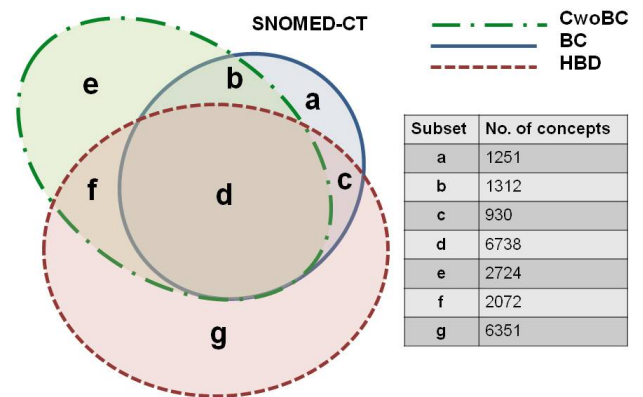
Sets of SNOMED-CT concepts for breast cancer (BC), cancer other than breast cancer (CwoBC) and heart and blood disease (HBD)
